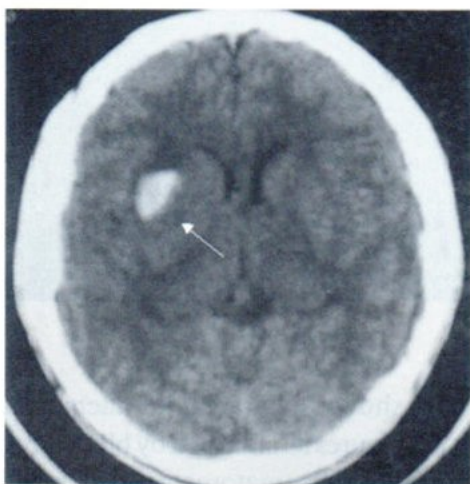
NC.CT. showed white mass indicated by the white arrow interpreted as a hematoma at the Rt. basal ganglia causing Lt. half paralysis.
